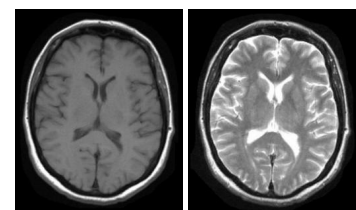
T1 (left) and T2-weighted (right) images. The contrast of the tissues is different: in T1-weighted images fat and white matter is bright, and in T2-weighted images grey matter and cerebrospinal fluid are bright.
